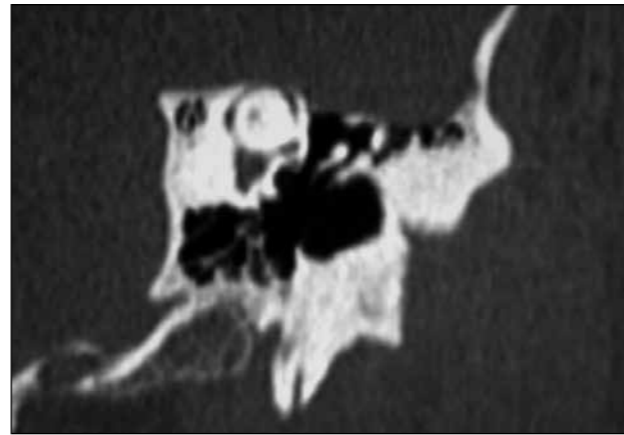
1 CT Scan showing superior canal dehiscence.
